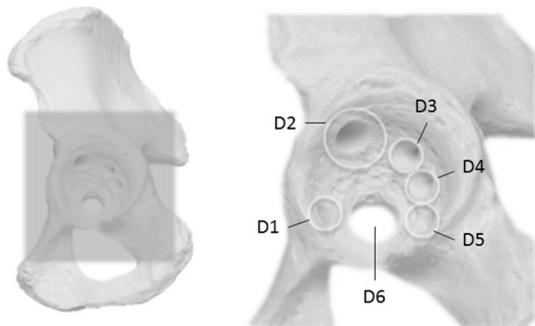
A Sawbone Model Nr. 1318 with 6 acetabular defects with different sizes are shown. The defect volumes were measured using a digitizer, a filling mould and by calculation of the volume out of 5 consecutive depth measurement and compared to a CT scan.
